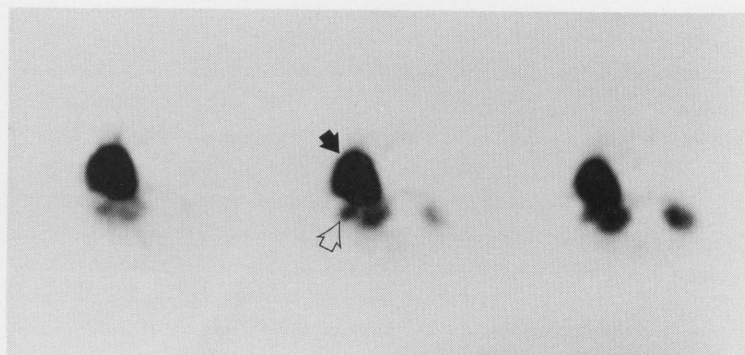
Massive uptake in the tumors consistent with those shown on CT scan is demonstrated on SPECT with In-111 pentetretotide.
